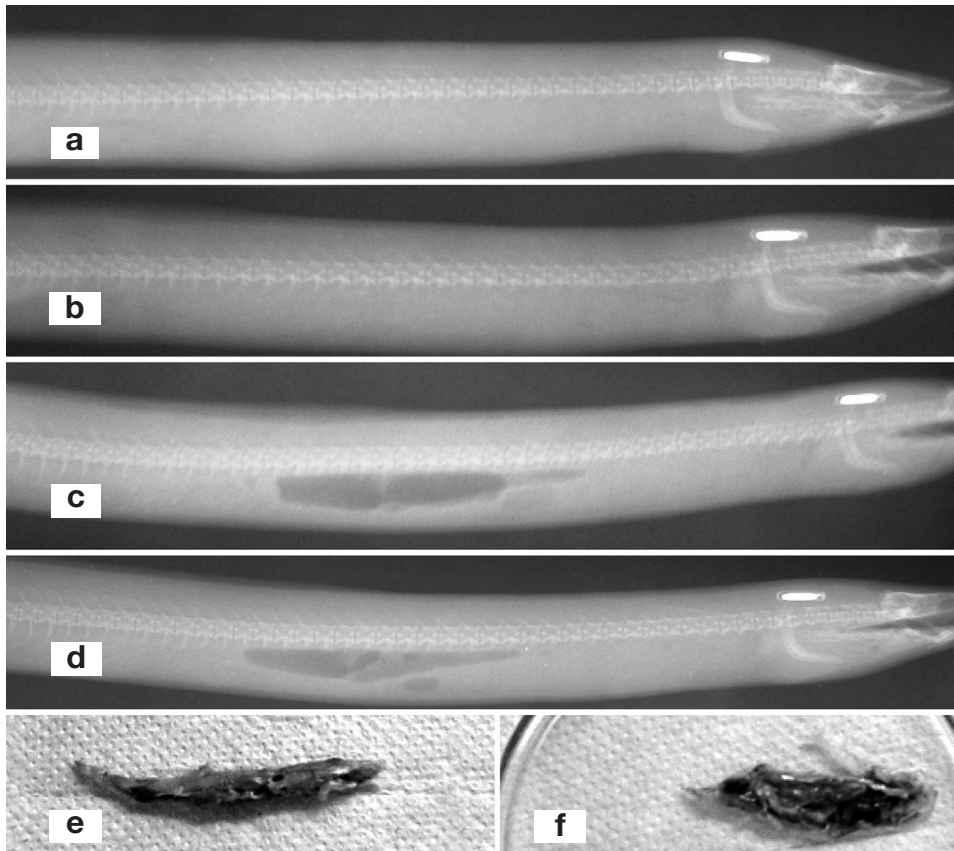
Anguillicola crassus* infecting *Anguilla anguilla*. Radiograph of Lake Balaton eel in the category 'severe swimbladder changes' at the first X-ray. (a–d) During the study, the status of the swimbladder initially remained unchanged, and later improved. (e) Swimbladder is opaque but contains air. (f) Wall of the swimbladder is thick (2.5 mm) and fibrotic, and the lumen contains 2 relatively small worms. By third X-ray, the swimbladder contours had become more pronounced, presumably because the majority of the large numbers of worms present in the lumen at the first and second X-rays had left the swimbladder through the pneumatic duct. Paleness of the anterior part of the swimbladder in (c) and the very pale contours of the swimbladder in (d) are indicative of gradual thickening of the swimbladder wall. Reductions: (a,c,d) $\times 0.6$, (b,e,f) $\times 0.7$
